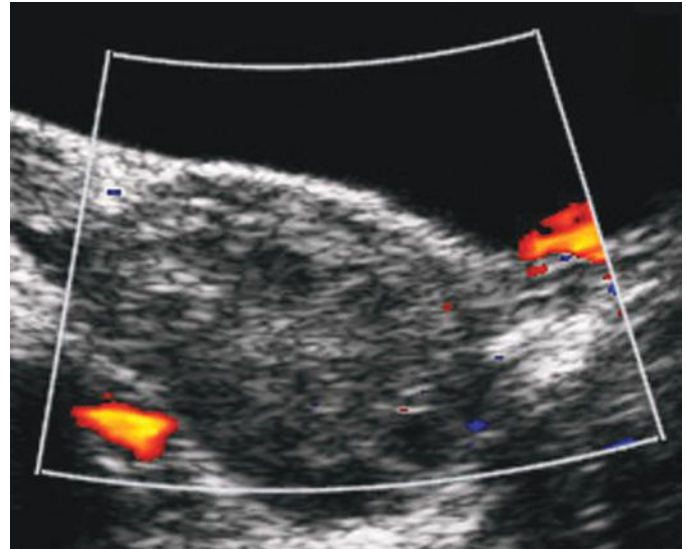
Adnexal torsion in a 14-year-old girl with a 3-day history of progressive right lower quadrant pain. Power Doppler ultrasound image of the right adnexa reveals an enlarged, avascular ovary with mildly enlarged, peripheral follicles. Right ovarian volume was 143 mL, and left ovarian volume was 13.7 mL (not shown). At surgery there was no associated right ovarian mass.
